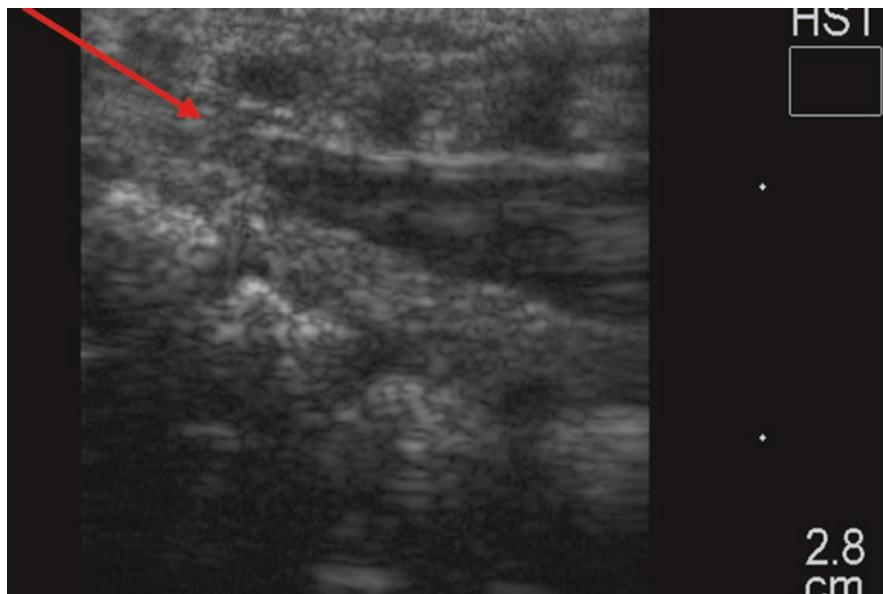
Ultrasound image of caudal space in a 6-month-old. Arrow pointing to sacral hiatus position. (Ultrasound image courtesy of Dr. Adrian Bösenberg (Bosie))
